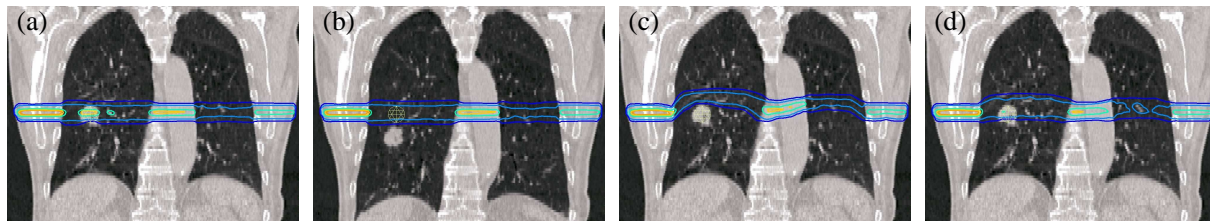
Beamlet warping: (a)/(b) beamlet doses calculated in the exhale/inhale CT of an example RCCT dataset, (c) beamlet dose of the inhale CT warped to the exhale reference geometry and (d) expected dose-to-moving-tissue of the beamlet,  $\langle T \rangle_{*j}$ , accumulated using all 8 CTs from the RCCT dataset according to eq. (4.5). Shown are the isodose lines of 95/70/40/10/5% isocentre dose for this beamlet as calculated with the pencil-beam algorithm.
